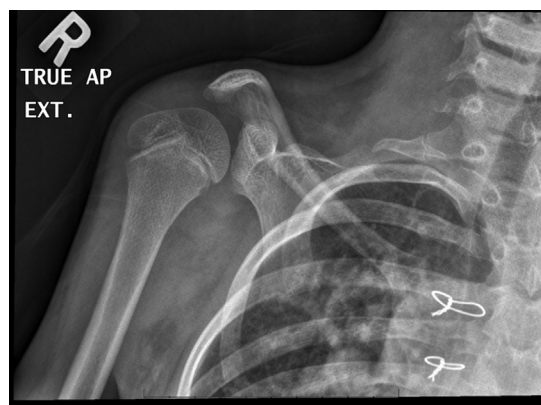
Anterior-posterior radiograph of the right shoulder showing complete absence of the acromion.
